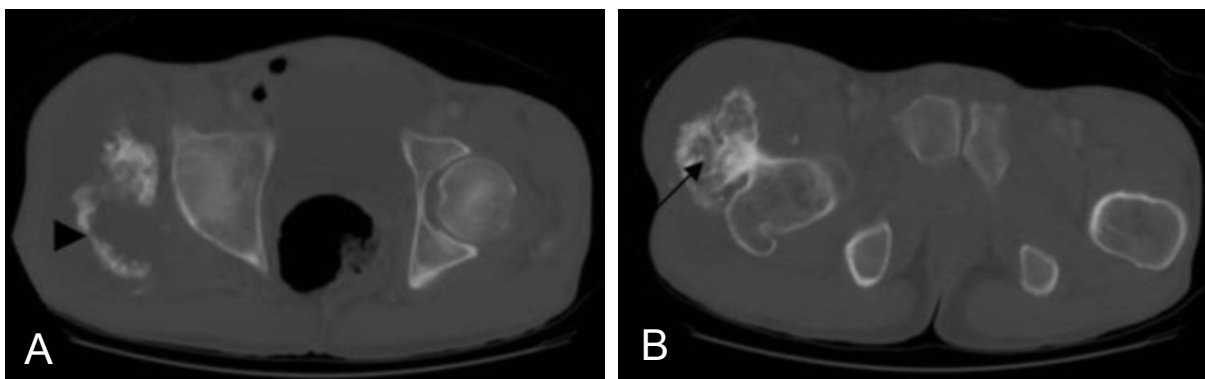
Transverse CT slices through the pelvis show (A) calcified fragment (arrowhead) and (B) osteochondroma (arrow).
